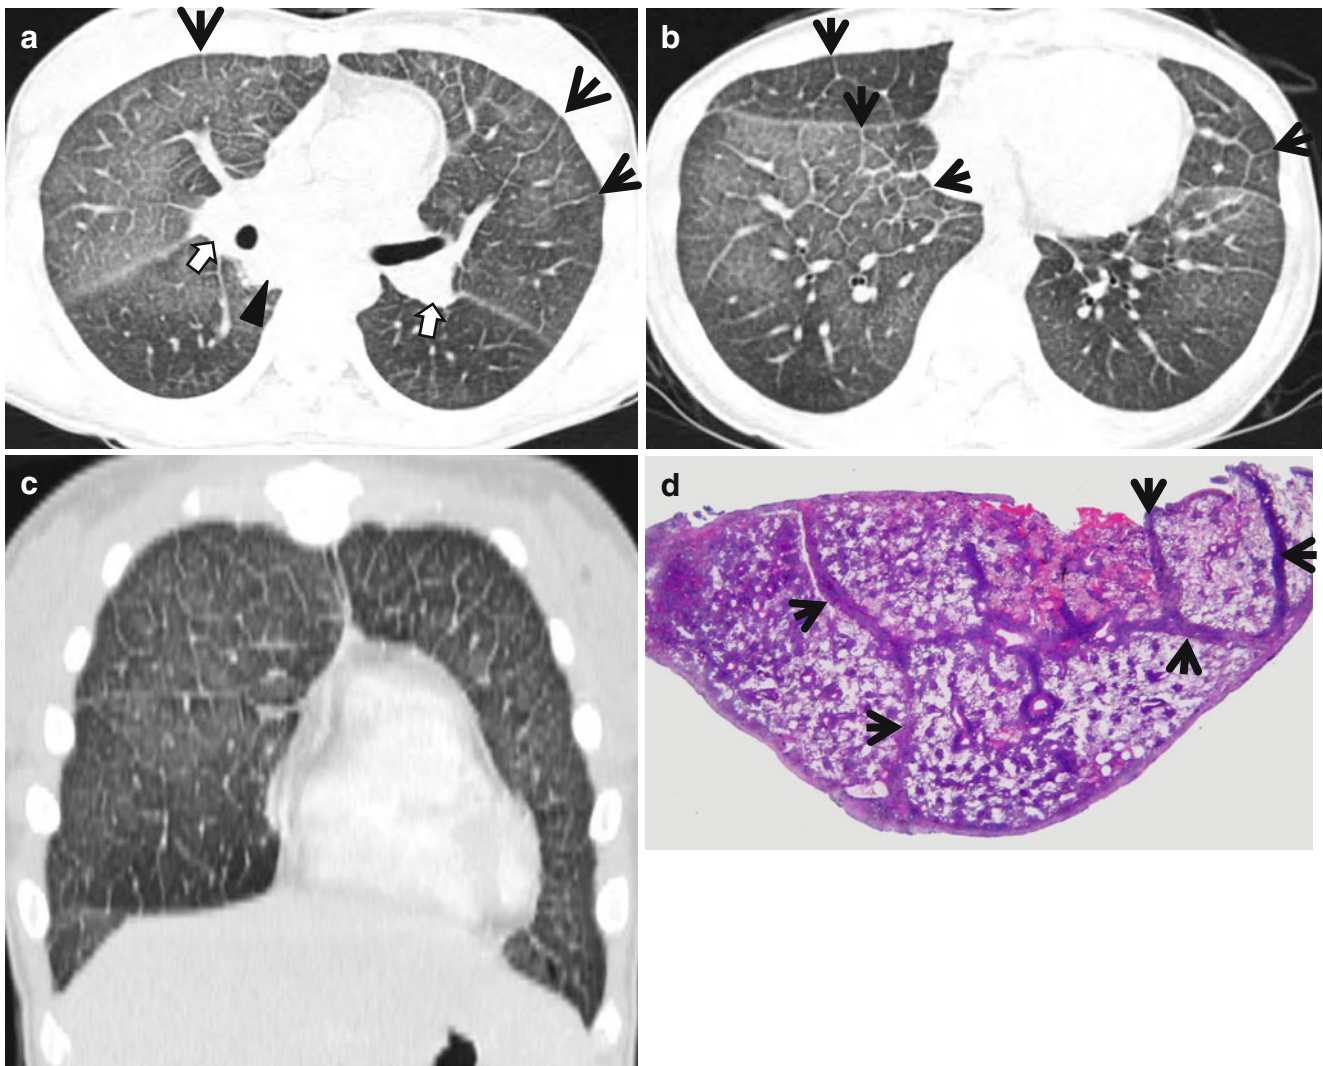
Smooth interlobular septal thickening with lymphomatous involvement of the lungs in a 27-year-old woman with diffuse large B-cell lymphoma. (a, b) Lung window of CT scans (5.0-mm section thickness) obtained at levels of bronchus intermedius (a) and suprahepatic superior vena cava (b), respectively, shows diffuse ground-glass opacity with smooth interlobular septal thickening (*arrows*) in both lungs, particularly in anterior lungs. Also note enlarged lymph nodes in bilateral hila (*open arrows* in a) and in subcarinal area (*arrowhead* in a). (c) Coronal reformatted image (5.0-mm section thickness) also
